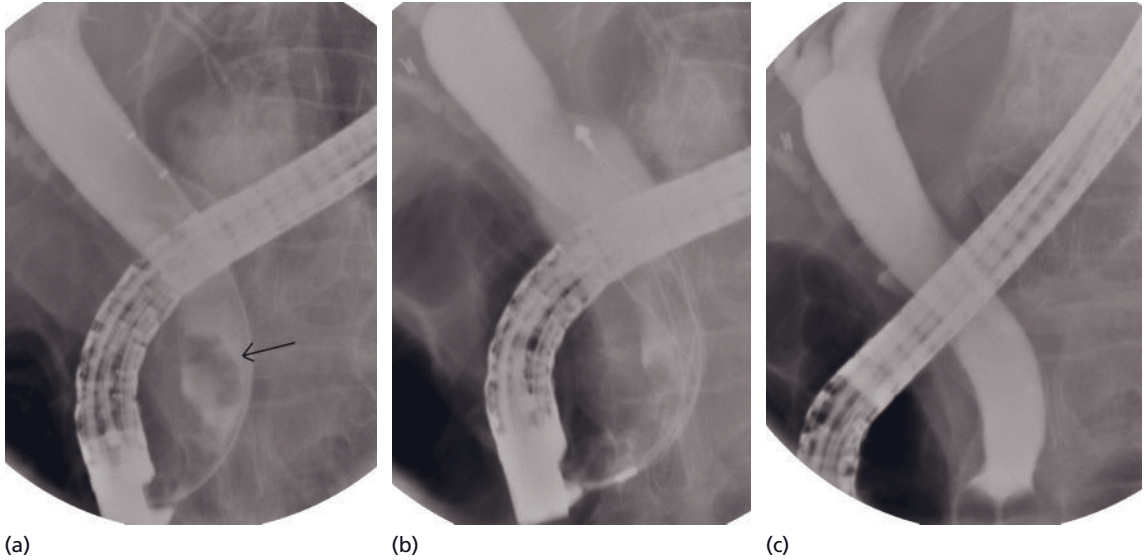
Removal of bile duct stones. (a) Radiographic image shows stone in distal bile duct (arrow); (b) Basket with stone captured; (c) follow-up cholangiography without bile duct stones.
